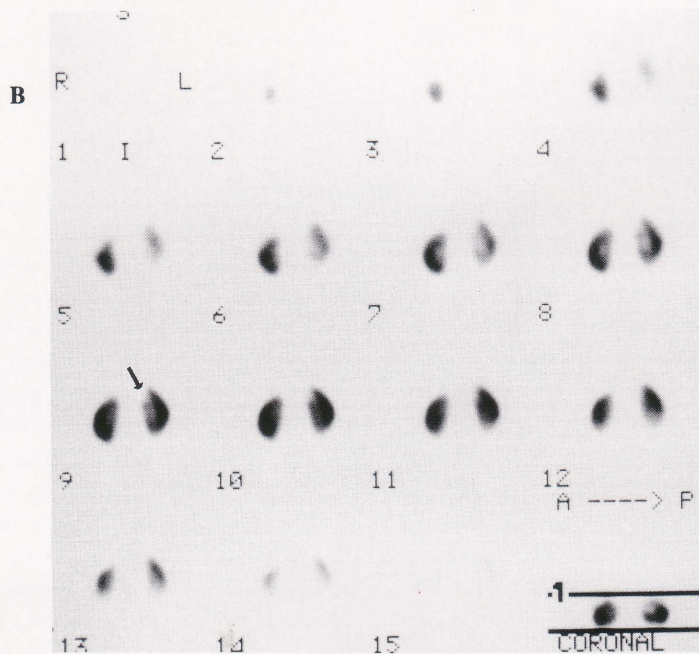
^{99m}Tc -DMSA renal scans (planar, SPECT-1, and SPECT-2) for detection of renal scarring. Figure 1A shows a false negative diagnosis in the renal planar scan. This scar is clearly demonstrated in both the SPECT-1 scan (Fig. 1B, arrow) and the SPECT-2 scan (Fig. 1C, arrow).
